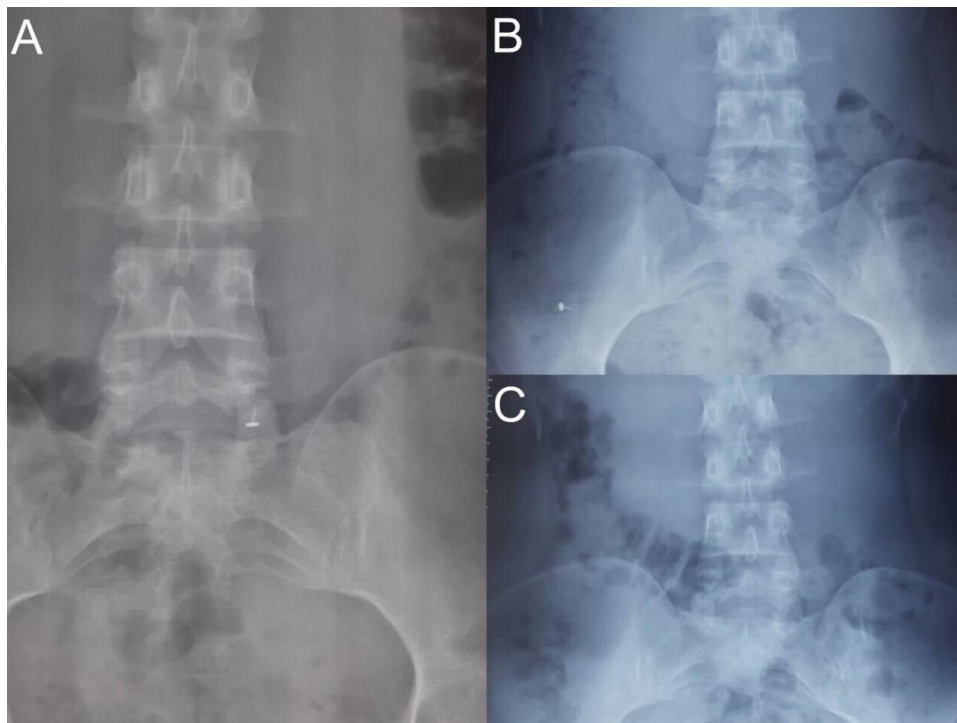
A plain X-ray of the abdomen showing a metal nose ring (A, B) in the GI tract, which is cleared subsequently (C)
